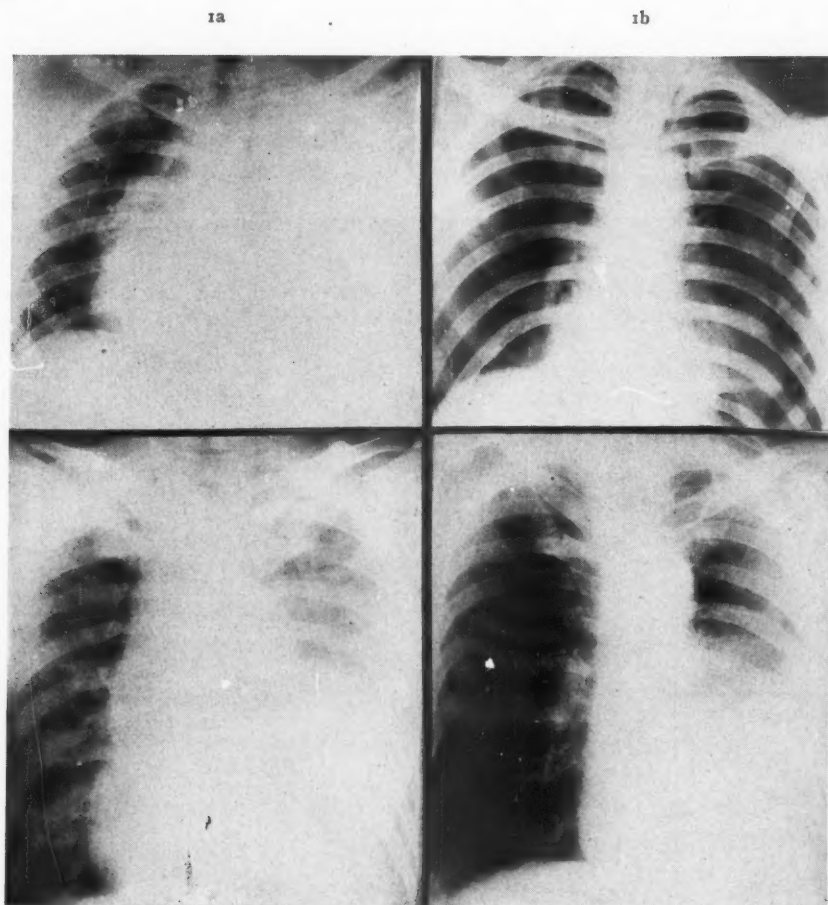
Case 1: (a) Roentgenograms of gunshot wound of left chest showing massive sterile hemothorax on admission June 25, 60 hours after injury. (b) This was followed by a pneumopyothorax (July 1) and the death of the patient on July 10. Excision of wounds of entrance and exit had *not* been performed.
